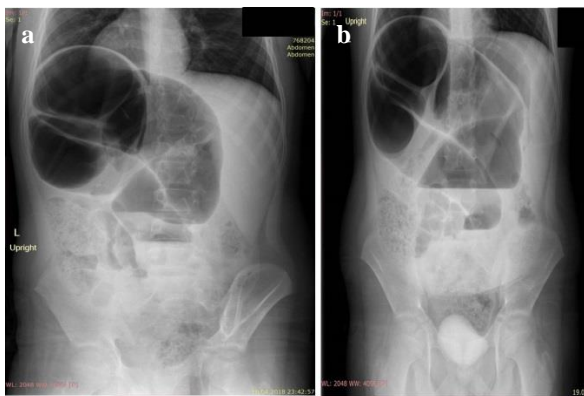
Abdominal X-ray demonstrating dilated colon segments, air fluid level, inverted "U" sign (a) First day of admission (b) Second day of admission.
